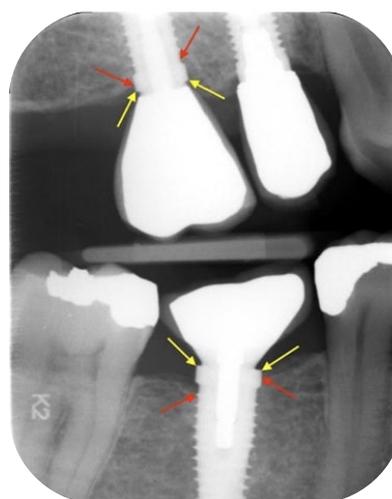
Radiograph showing reference point (yellow) and crestal bone level (red)
